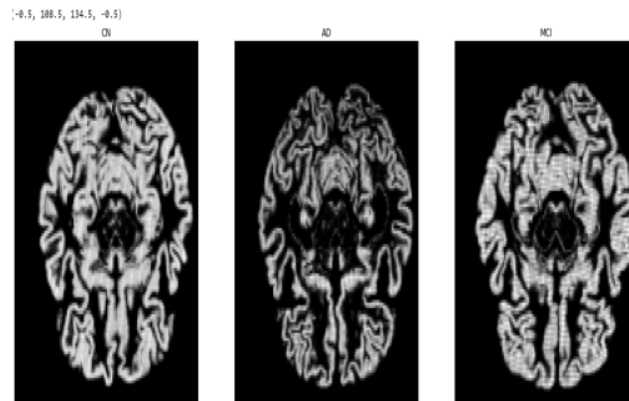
A 2d view of a slice of MRI images of different stages of AD
